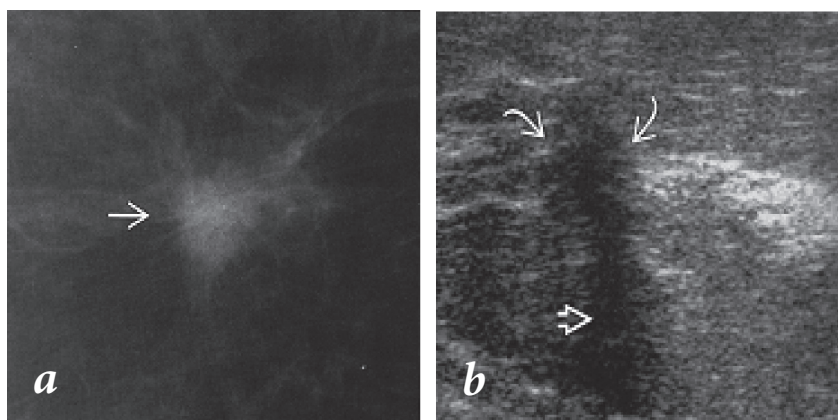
Images of infiltrating ductal carcinoma: mammogram (a) and ultrasound (b).
